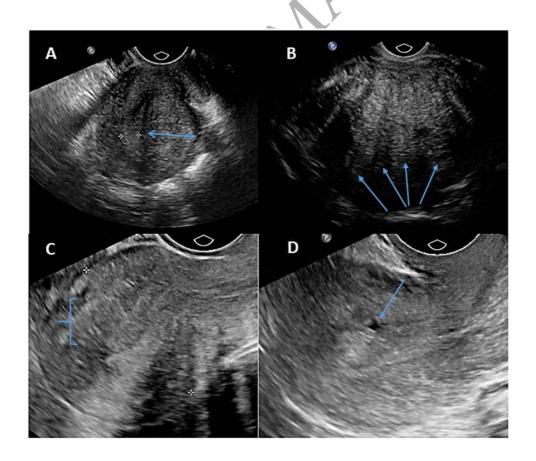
Sonographic Features of adenomyosis
